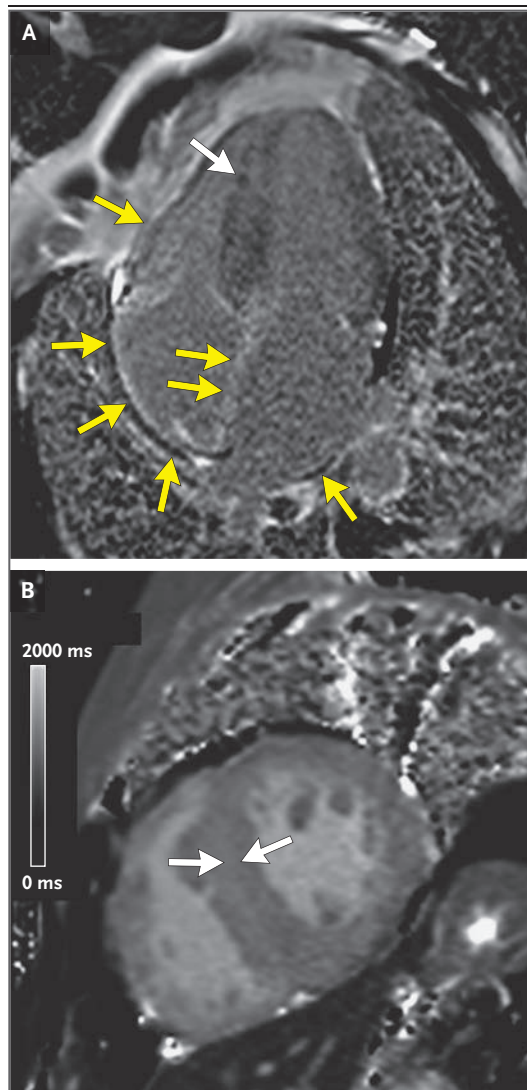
Repeat Cardiac MRI.
